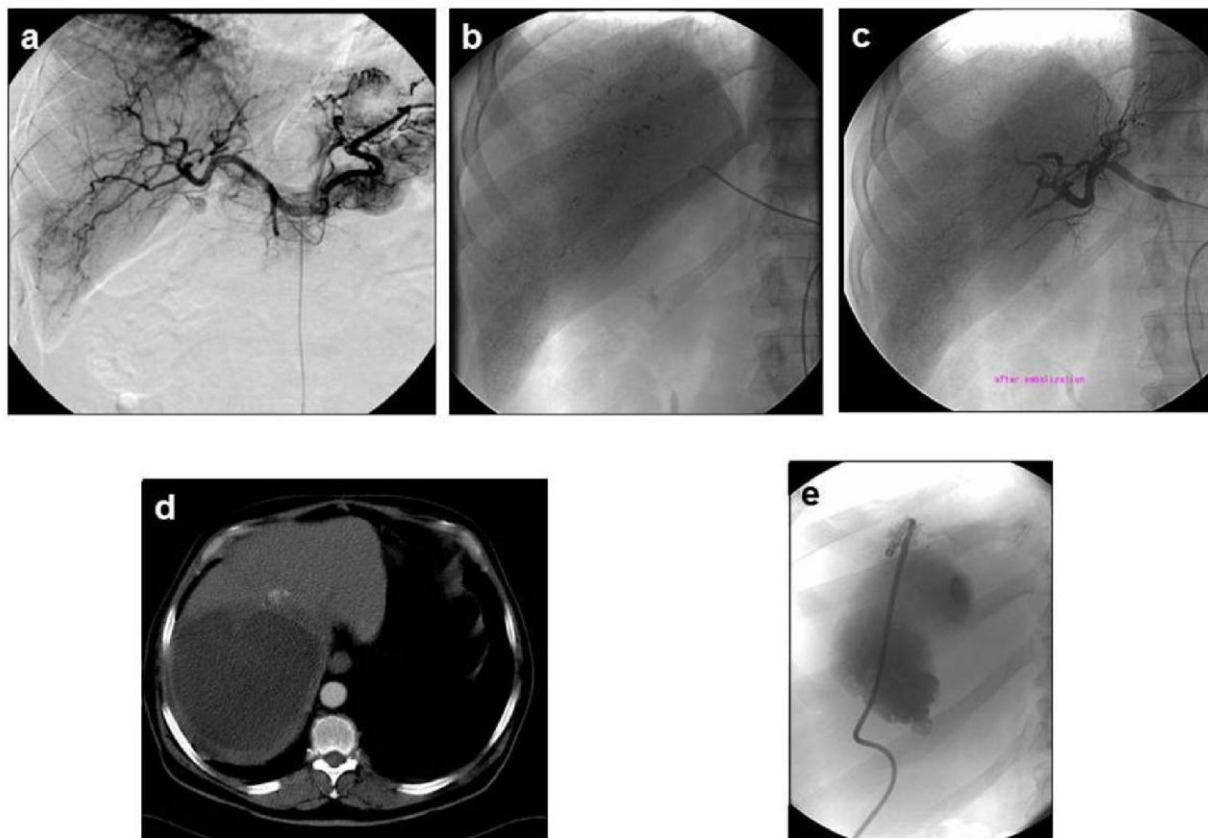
Liver abscess. 63 years old male hepatic metastatic melanoma patient underwent 'dense' chemoembolization with iodized oil and carboplatin: (a) hepatic arteriography, (b) accumulation of iodized oil in the liver, (c) absence of blood flow in the peripheral hepatic arteries confirmed by post-TACE arteriography. CT (d) two months after TACE revealed right lobe liver abscess requiring percutaneous drainage (e) with bile fistula formation.
